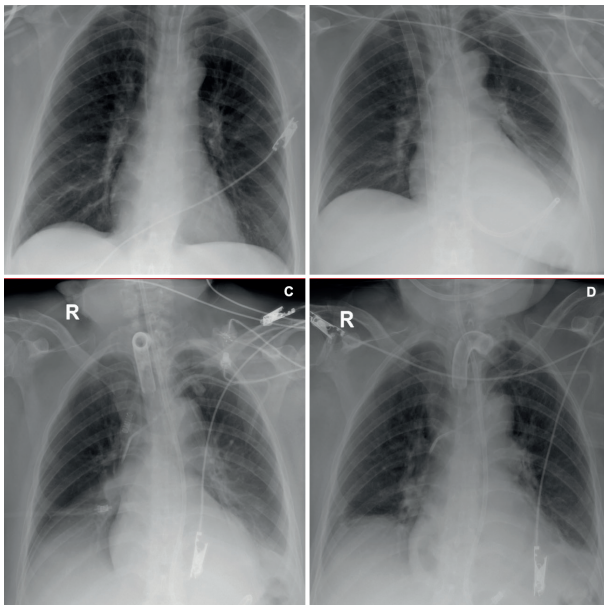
Sequential chest X-ray of case 4. A. Chest X-ray with adequate pulmonary expansion, orotracheal tube correctly positioned. B. A left basal opacity is identified, secondary to pleural effusion with increased retrocardiac density due to atelectasis/consolidation, presence of ECMO cannula in right jugular vein. C. Tracheostomy cannula, pulmonary congestion and bilateral pleural effusion. D. Tracheostomy cannula, unremarkable pulmonary hila, subsegmentary bilateral basal atelectasis with small pleural effusion, enteral feeding tube and left subclavian catheter.
